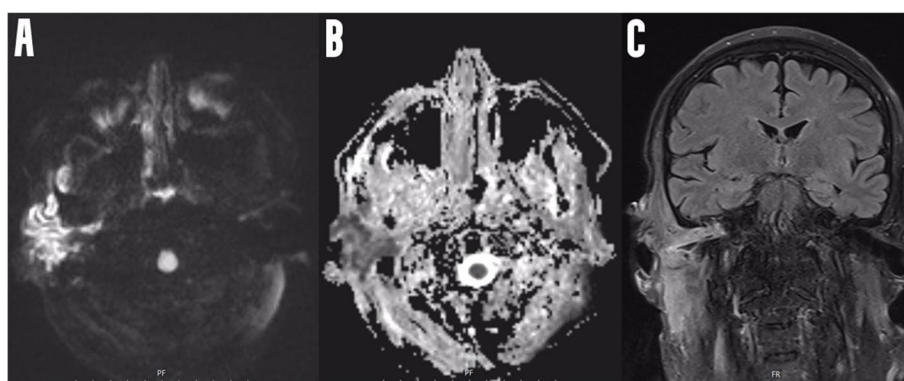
Diffusion-weighted imaging (DWI) (A) MRI and the corresponding ADC maps (B) revealed restricted diffusion in right ear canal, mastoid and petrotic skull base. Sagittal fluid attenuated inversion recovery (FLAIR) (C) sequences showed marked hyperintensity due to edema extending longitudinally and centrally beyond of ear canal and structures
